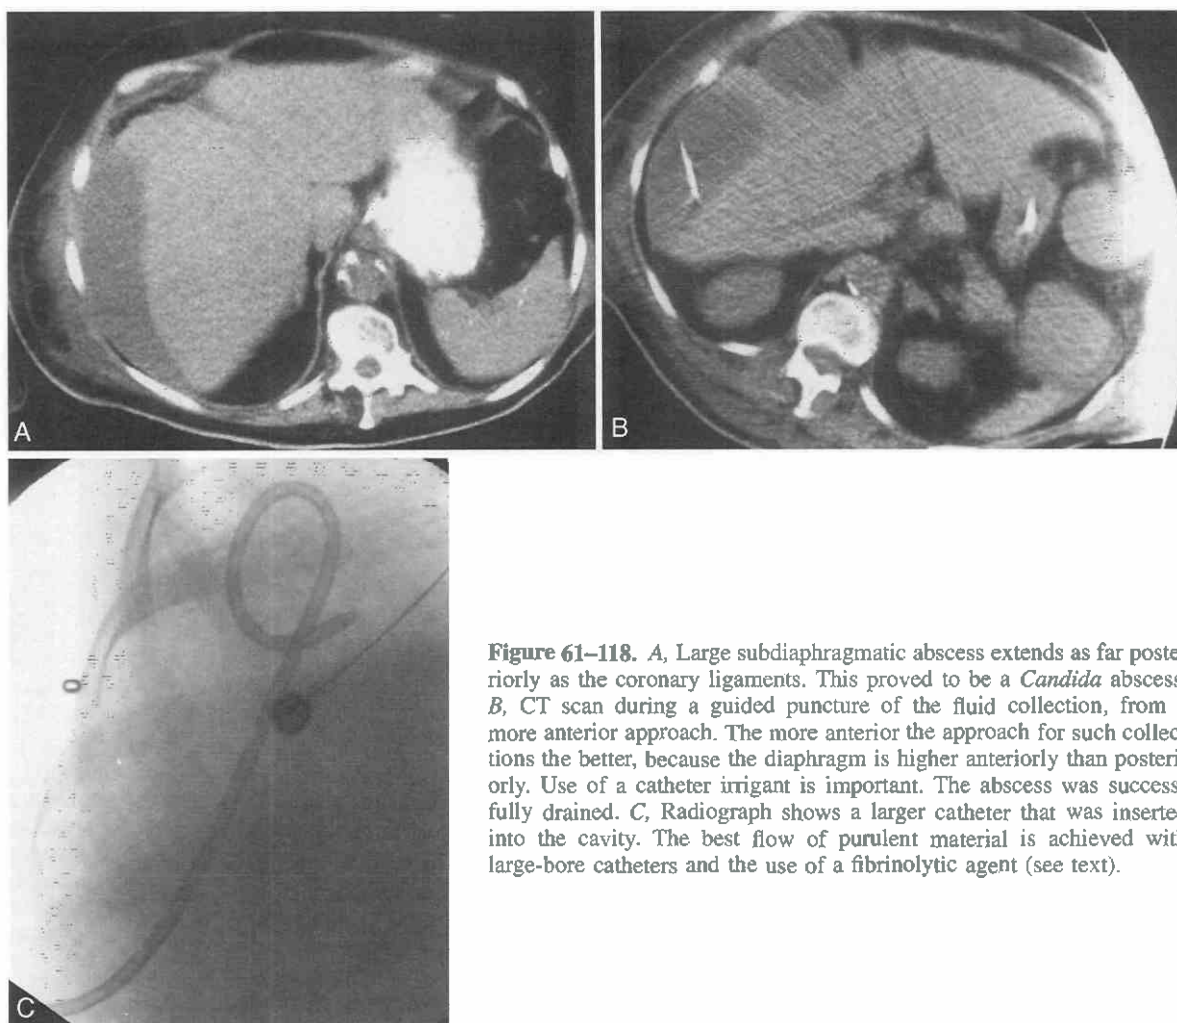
A, Large subdiaphragmatic abscess extends as far posteriorly as the coronary ligaments. This proved to be a *Candida* abscess. B, CT scan during a guided puncture of the fluid collection, from a more anterior approach. The more anterior the approach for such collections the better, because the diaphragm is higher anteriorly than posteriorly. Use of a catheter irrigant is important. The abscess was successfully drained. C, Radiograph shows a larger catheter that was inserted into the cavity. The best flow of purulent material is achieved with large-bore catheters and the use of a fibrinolytic agent (see text).
